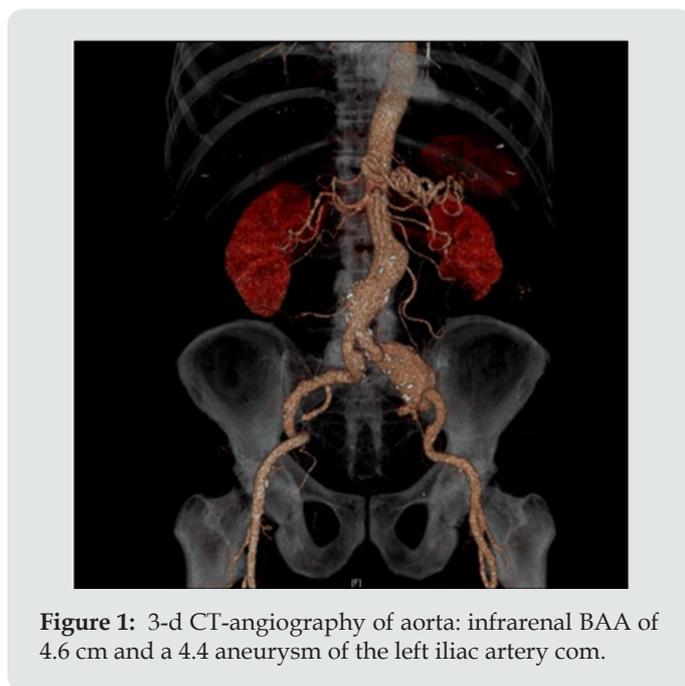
3-d CT-angiography of aorta: infrarenal BAA of 4.6 cm and a 4.4 aneurysm of the left iliac artery com.
